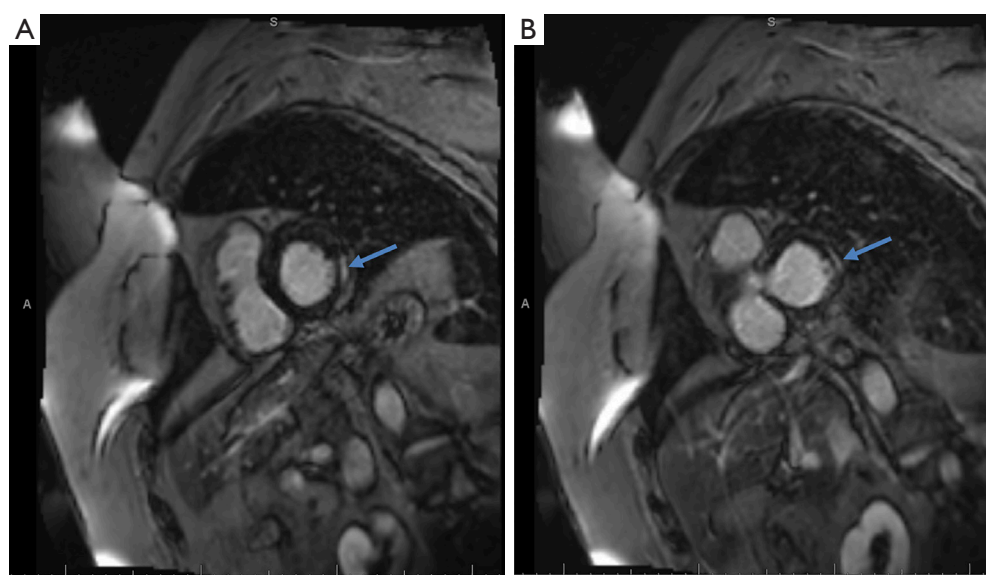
Cardiac MRI showing interval decrease in delayed gadolinium enhancement in the anterior lateral (A) and inferior lateral (B) segments of the left ventricle (arrows). MRI, magnetic resonance imaging.
